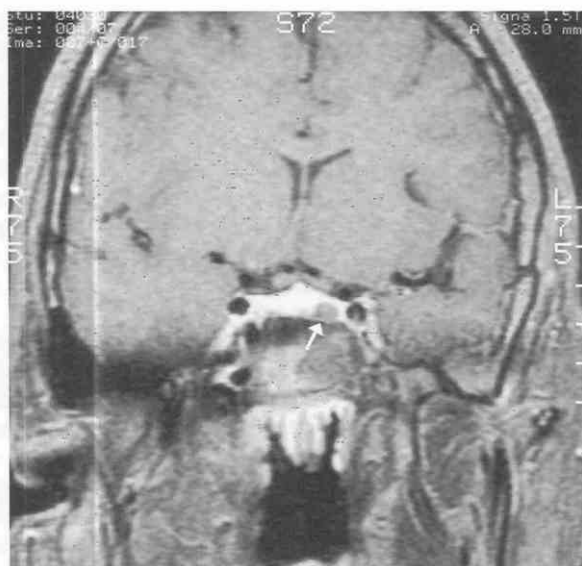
Pituitary microadenoma. Coronal T1-weighted MR image obtained during a dynamic scanning sequence following bolus intravenous administration of gadolinium. A 5 mm in diameter ovoid hypointense lesion in the left inferior aspect of the pituitary gland (arrow) fails to take up the contrast medium as rapidly as the surrounding normal pituitary tissue.
